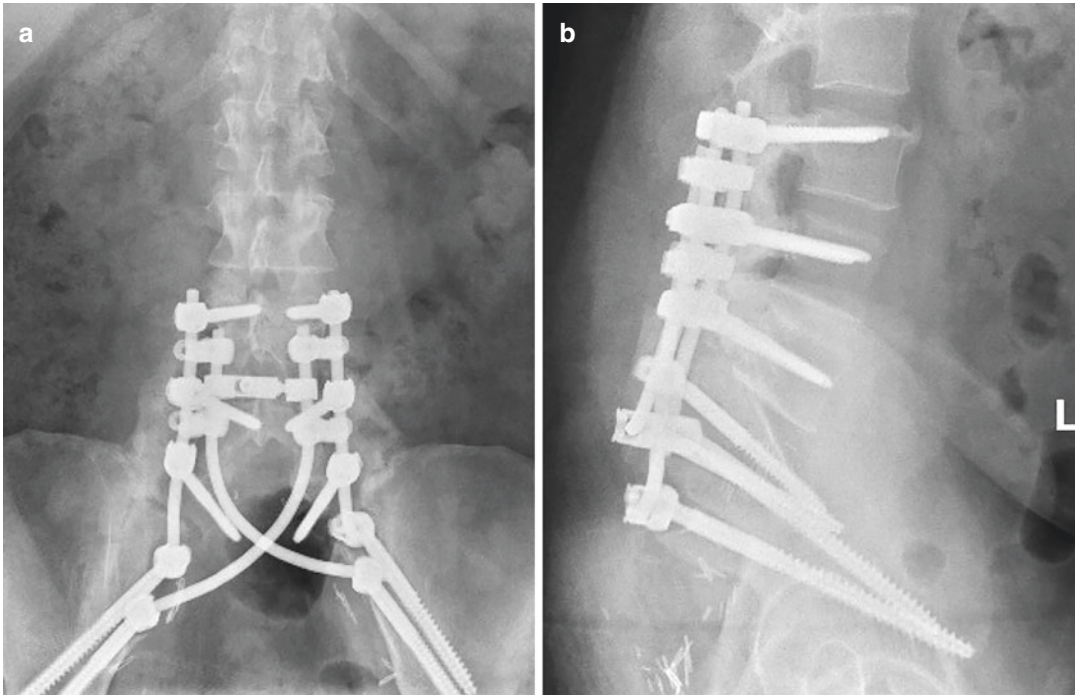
(a) AP plain film X-ray of lumbo-pelvic reconstruction following total sacrectomy for chordoma. Patient ambulatory following surgery. (b) Lateral view of lumbo-pelvic reconstruction
